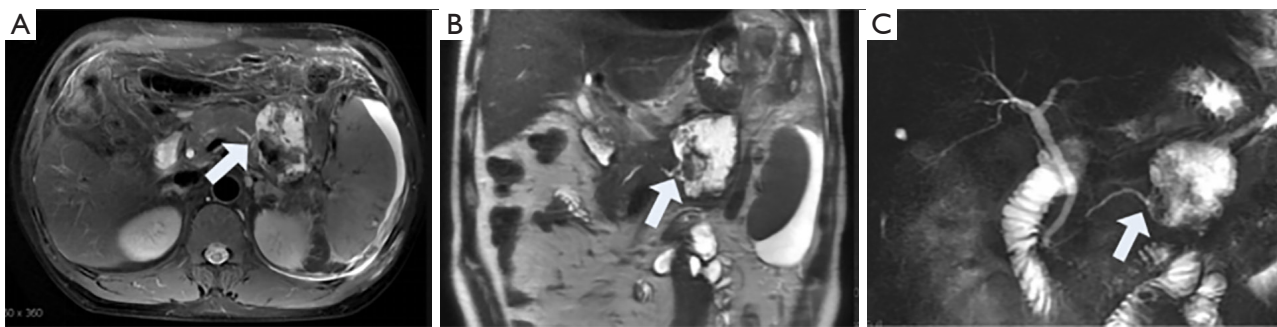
Disconnected pancreatic duct syndrome in a 37-year-old woman with acute necrotizing pancreatitis. The axial T2-weighted image (A) and coronal T2WI (B) obtained 7 weeks after onset show an area of WON with diameter of 6 cm located in the pancreatic body and tail. The pancreatic duct in the pancreatic body is dilated, abruptly cut off, and connected with the area of WON (C, arrow). WON, walled-off necrosis.
